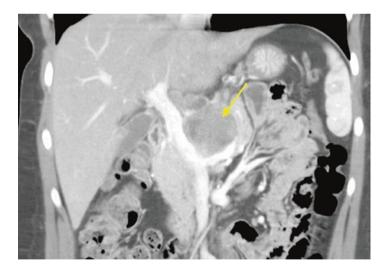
CT scan of the abdomen demonstrating a solid pseudopapillary tumor in a young female patient slightly compressing the portal venous confluence under the neck and body of the pancreas.
